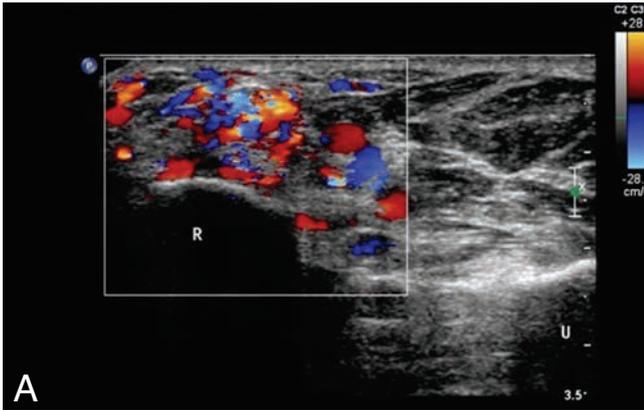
Color Doppler at the level of the anastomosis zone (A): the muscular collaterals which are difficult to distinguish from the stardust artifact in this single plane view. Triplex of a muscular arterial collateral (B): identical systolodiastolic flow (arrow) to the one of the ulnar artery.
